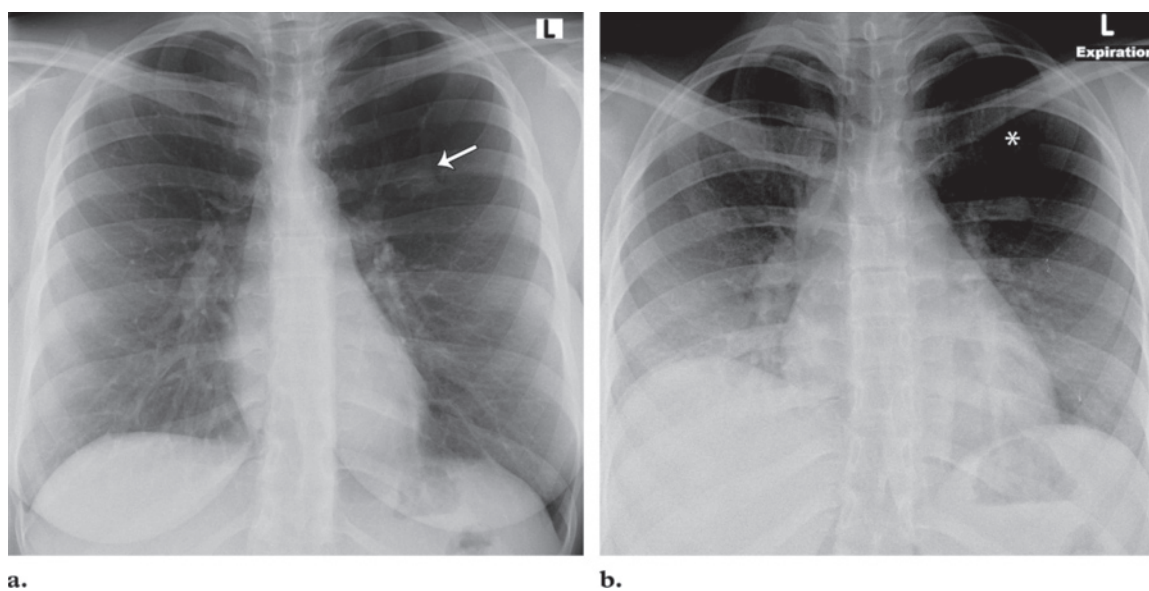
(a) Inspiratory radiograph obtained 2 years earlier shows a bronchocele in the left upper lobe (arrow). (b) Exhalation radiograph shows an area of hyperlucency (*) surrounding the area of increased opacity, a finding indicative of air trapping.
